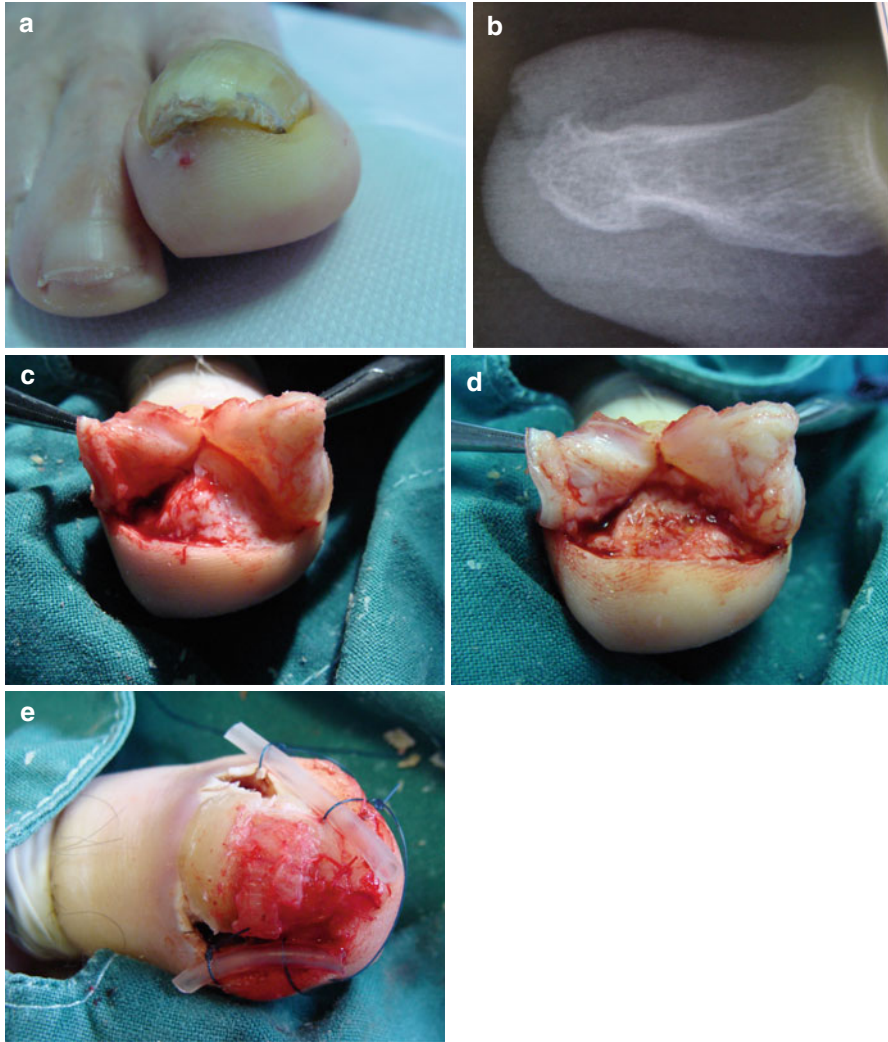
(a) Painful thick pincer nail. Was thought to be onychomycosis and treated for so without any results (b) X-rays lateral view showing a prominent dorsal distal tuft (c) elevation of two lateral flaps of the bed reveals the distal tuft (d) after removal with a bone rongeur (e) after suturing the bed and expanding the bed with reverse tie over sutures
